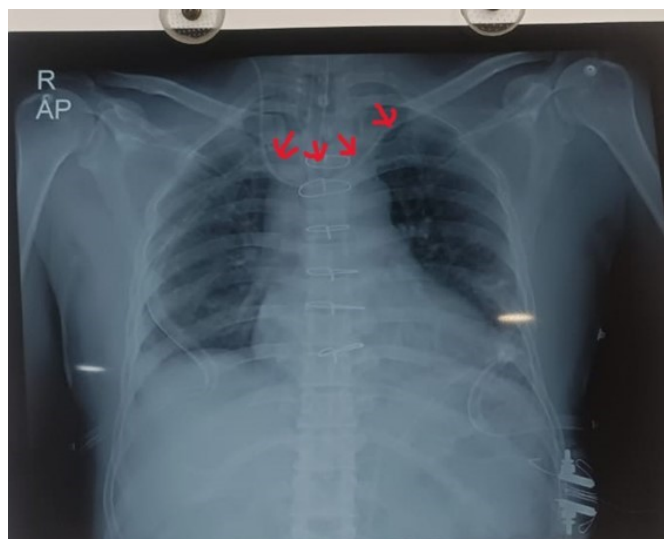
Chest X-Ray , AP view shows that the CVP catheter from RIJV has entered the left innominate vein, the course is followed by the red arrows. The lung fields and cardiac shadow appears to be normal. In addition, sternum closure with steel wires can also be observed.
